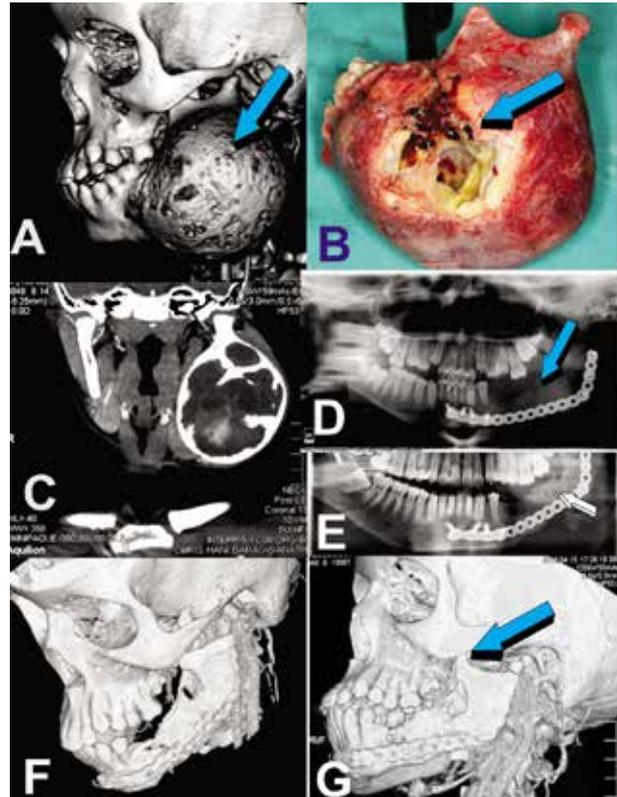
Clinical translation of the substantial induction of bone formation by 250 μg of recombinant human transforming growth factor- β_3 (hTGF- β_3) pre-combined with coral-derived macroporous bioreactors implanted in the *rectus abdominis* muscle of the Chacma baboon *Papio ursinus*.^{17,24} A. Aneurismal bone cyst shown by three- and two-dimensional CT scans (C). B. Resection resulted in 13 cm long defect of the mandible. The defect was reconstructed with a 6 cm costo-chondral graft and with 2500 μg hTGF- β_3 pre-combined with 12 g of human demineralized bone matrix (hDBM). D. Panoramic radiograph of the implanted hemi mandible 15 days after implantation of 12 g of hDBM reconstituted with 2500 μg hTGF- β_3 packaged within mandibular defect (light blue arrow). E. Panoramic radiograph 6 years after reconstruction. Regeneration of the avulsed mandible with restoration of mandibular morphology. F.G. 3D reformatted CT scan of the mandible 6 months post reconstruction. The granular DBM has been replaced by a cohesive bone ossicle with regeneration of a condylar and coronoid process (light blue arrow).
